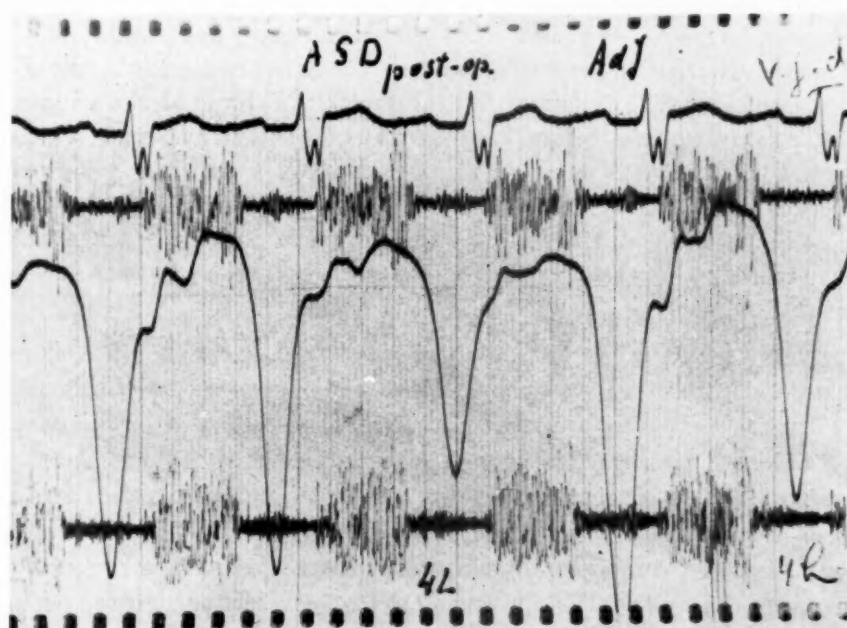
Atrial septal defect of the primum type after closure of the defect. In the venous tracing a small *a* wave is present, and the *a*, *c*, and *v* waves merge into one positive wave, indicating tricuspid insufficiency. Compatible with this diagnosis are the pansystolic and mid-diastolic murmurs in the phonocardiogram, recorded at the fourth intercostal space parasternally.
